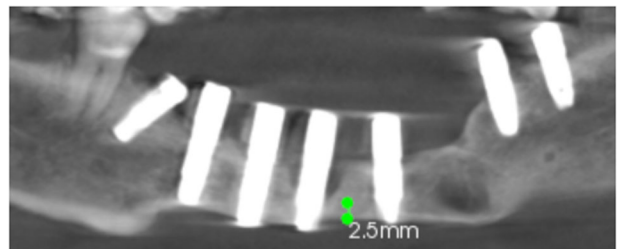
Radiograph showing extensive bone loss.
